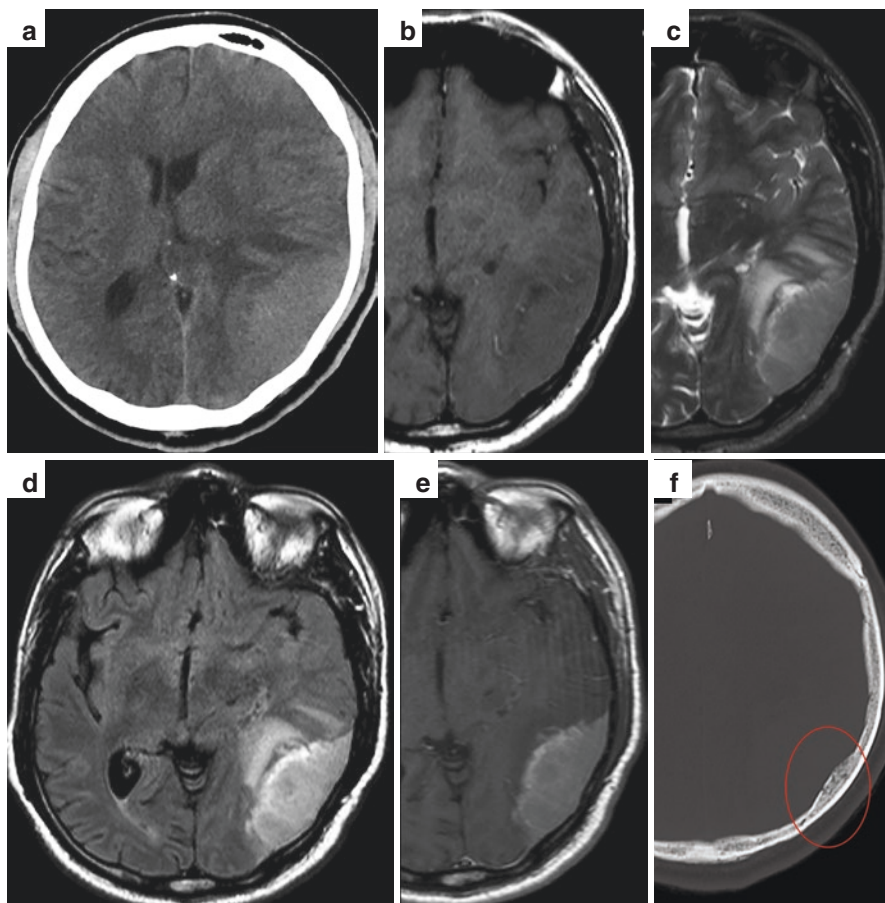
Cranial CT (a, f) and MRI (b–e) images of a 55-year-old male patient. In the unenhanced axial CT image with a parenchyma window (a), an extra-axially located isodense (to the gray matter) lesion is observed in the left parieto-occipital region. The lesion is observed as isointense on T1 (b) with gray matter, iso-hyperintense on T2 (c), and hyperintense on FLAIR (d). A hyperintensity of edema due to mass effect is accompanied by T2 and FLAIR sequences in the adjacent cerebral parenchyma. On contrast-enhanced T1 (e), the lesion is observed to have a distinctly homogeneous enhancement. In the bone window axial CT image (f), the thickness of the adjacent bone is increased due to hyperostosis. Findings support the meningioma
